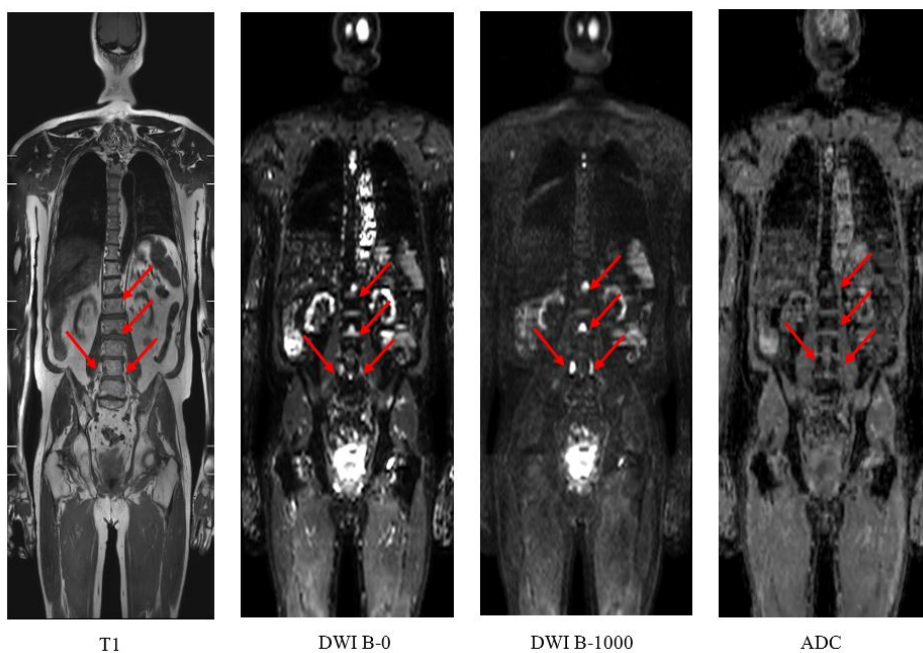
Different sequences of WB-MRI with the best diagnostic outcomes. Red arrows pointed to the bone metastases
